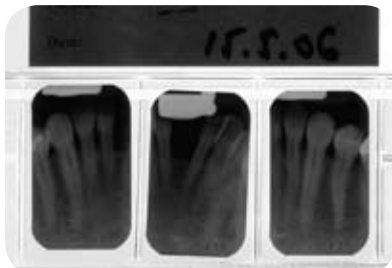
Periapical radiographs showing around one-third bone support for the roots of the anterior lower incisors.
